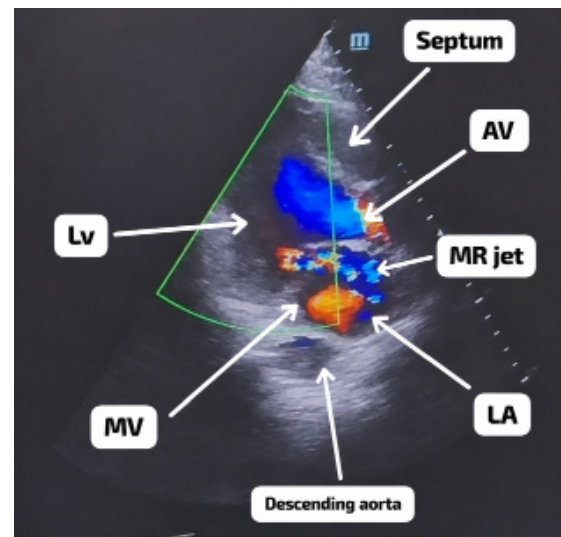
Color Doppler echocardiographic image demonstrating severe mitral regurgitation jet across the mitral valve in the absence of valvular vegetations.
